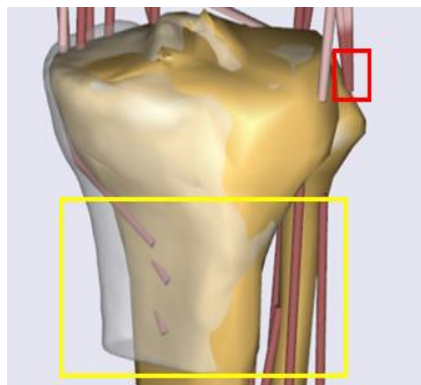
Discrepancy (less overlapping) between generic morphed bone (Gold) and the target bone (transparent white) in tibia bone morphing. Yellow rectangle shows the region where discrepancy was the highest mainly because no landmarks were selected for the morphing process. As a result, the three muscle attachments were not morphed. The red rectangle locates the insertion points of the biceps femoris muscles on the fibula head. This region was not morphed as well because fibula bone was not segmented from the MRI scan.
